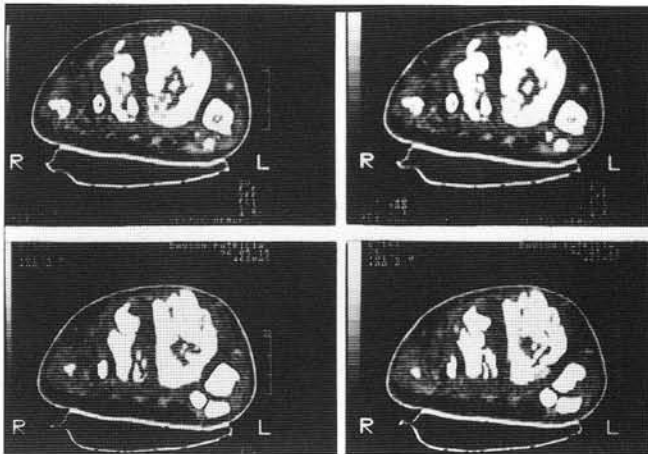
The CT scan shows the osseous mass circumferentially around the second and third metatarsals. Surgical exploration and removal confirmed "exuberant, reactive bone formation" with a foci of fractures through the second and third metatarsal shafts. The autonomic neuropathy and hypervascular state accounted for this benign bone formation in the soft tissues.
